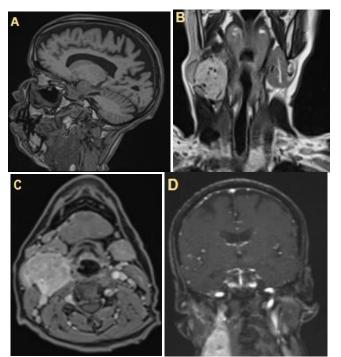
Magnetic resonance imaging (MRI) of the brain showing right glomus carotid lesion in different phases of acquisition T1 and T2 without contrast agent injection (A, B), T1 with contrast agent injection (C), TOF sequence (D). Vascular flow void present within the lesion
